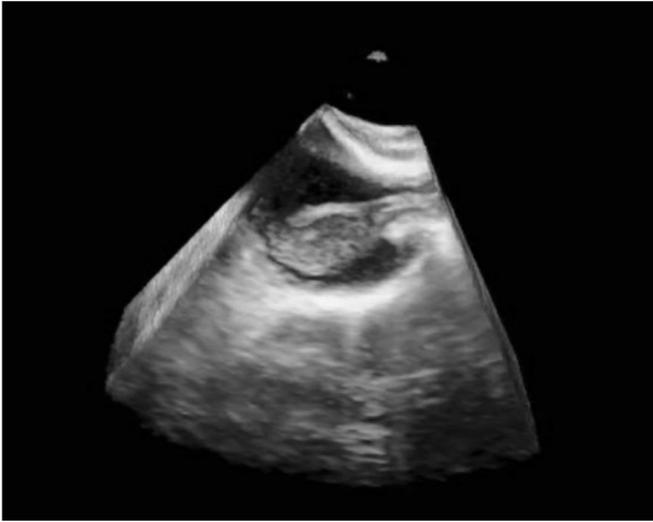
Fibrin sheath seen in the right atrium during transthoracic echocardiogram long-axis view (three-dimensional image).
